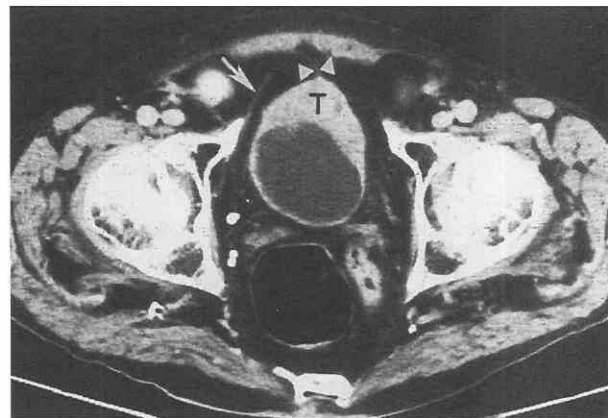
Confined bladder cancer. CT scan through bladder tumor (T), outlined by urine, of stage T2 or earlier on the anterior wall. Incidental note is made of the median (arrowhead) and medial (arrow) umbilical ligaments.
